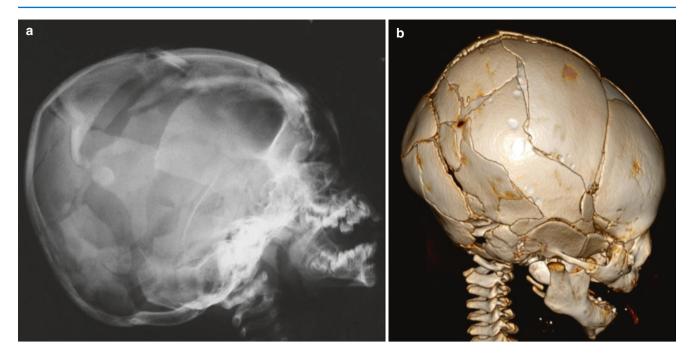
(a) Skull radiograph of an infant who died after being thrown from the fifth floor of an apartment building by her caretaker. Extensive comminuted diastatic skull fractures. (b) 3D CT reconstruction of another patient with extensive comminuted fractures
